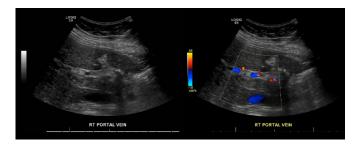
Echogenic intraluminal material in the right portal vein with no flow on color-flow doppler.
